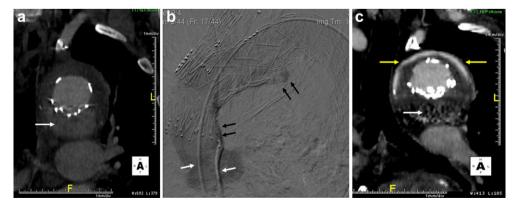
(a) Postoperative CT angiography at 6 weeks showing a significant type Ia endoleak (white arrow) (b)Type Ia endoleak due to protrusion of proximal stent into the aortic lumen at the minor curve. A reversed curve catheter has been placed in the stent graft (white arrows). Contrast infusion through the catheter demonstrates the endoleak (black attows), (c) postoperative day one CT angiography, following coiling and gluing of the aortic aneurysm sac. The white arrows indicate some contrast-mixed glue within the aneurysm sac, yet no evidence of obvious ongoing endoleak.
